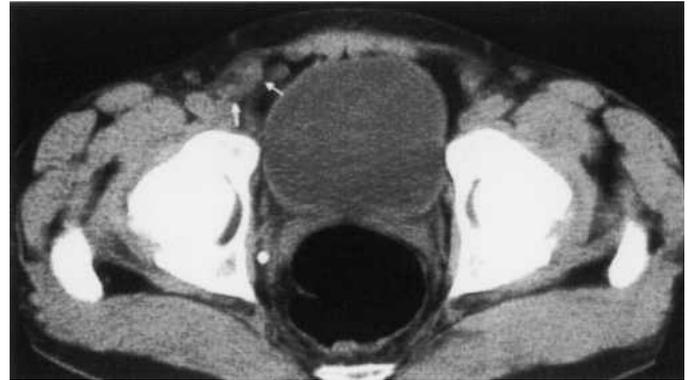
Computed tomography (CT) scan of a meshoma formed by wrinkling of the deep layer of a bilayerPHS (Prolene Hernia System) hernia device.
